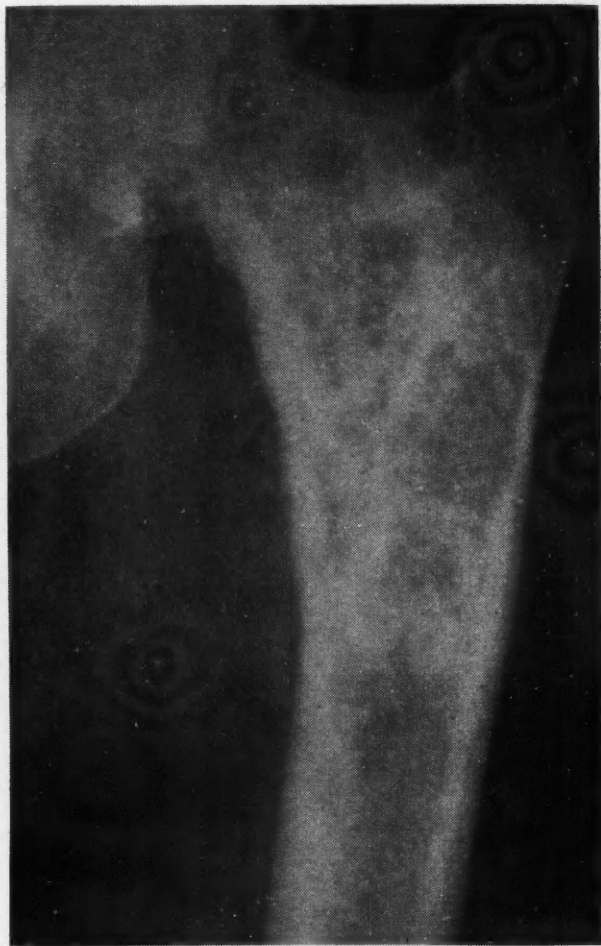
(b).—Radiograph, February 15, 1955 (had adrenalectomy January 28, 1954). Note again dense recalcification throughout entire area of involvement associated with complete relief of presenting symptoms.
